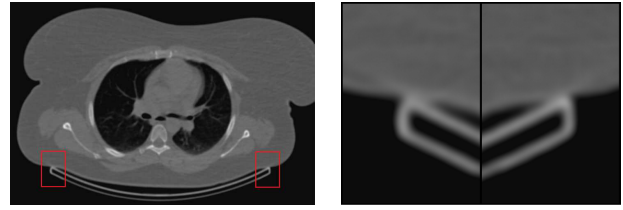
An axial CT slice where the patient couch is connected with the patient (left). The magnified regions of the red rectangles (right).
